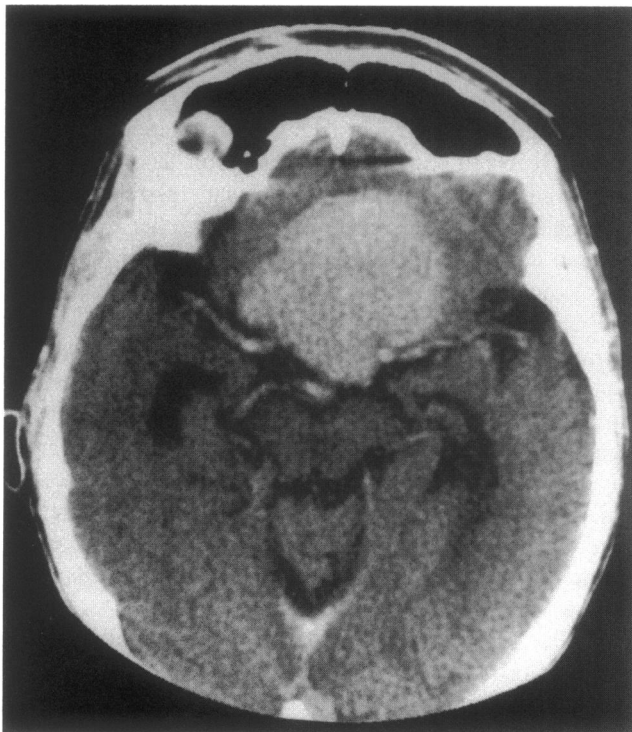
Contrast enhanced CT (A) and coronal T1-weighted MRI (B) of an 82-year-old woman with deteriorating vision (case 9). The tumor has homogenous enhancement and minimal sellar enlargement compared with the suprasellar extension, more typical of the appearance of a meningioma. The left anterior cerebral artery (A-1 segment) can be seen to be elevated and to course through the tumor (arrows).
